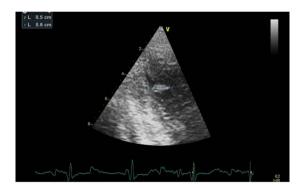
The echocardiography showed a small apical thrombus.
